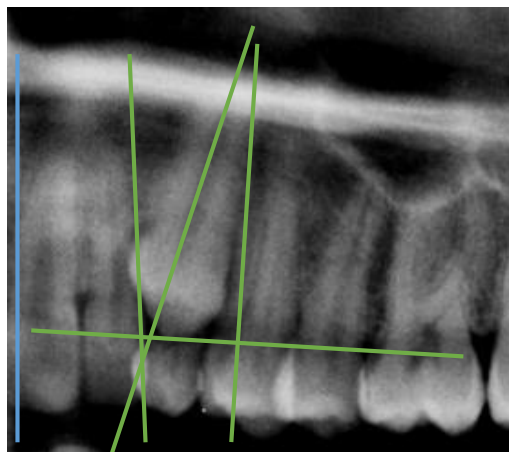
Close up panoramic radiograph of 2nd quadrant. Good prognostic of traction, according to the *Stivaros et al.* (2000) article ⁽⁶³⁾.
